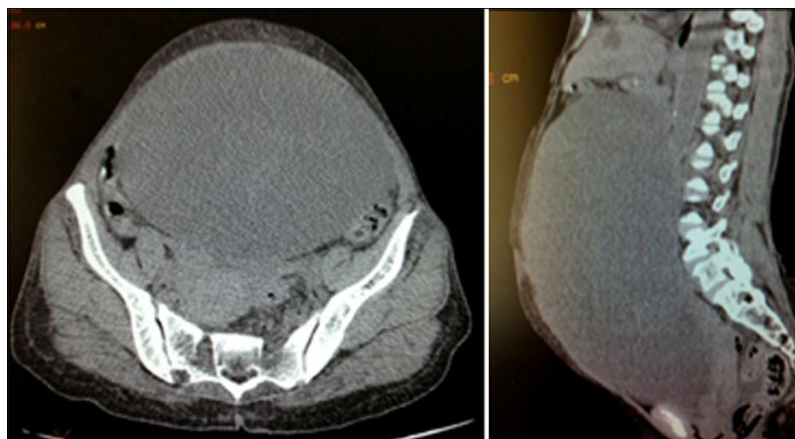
Axial and sagittal CT scan images showing large cystic lesion with thin septa arising from pelvic- serous cystadenoma.
